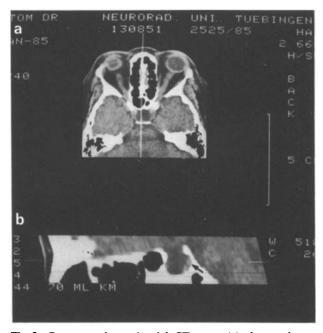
Contrast-enhanced axial CT scans (a) show enlargement of the optic nerves and of the sella. CSF densities occupy most of the sellar volume. On the sagittal reformatted image (b) the remaining pituitary gland can be seen flattened against the posterior aspect of the dorsum (arrow)
